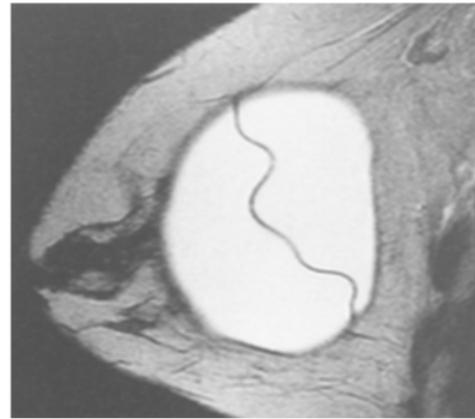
Sagittal fast spin-echo T2-weighted water-suppressed MR image of single-lumen, silicone gel-filled implant with smooth implant shell. A normal fold of the implant shell, seen here as a dark thin line "within" the gel, can be seen extending all the way across the implant (Middleton and McNamara, 2000).
